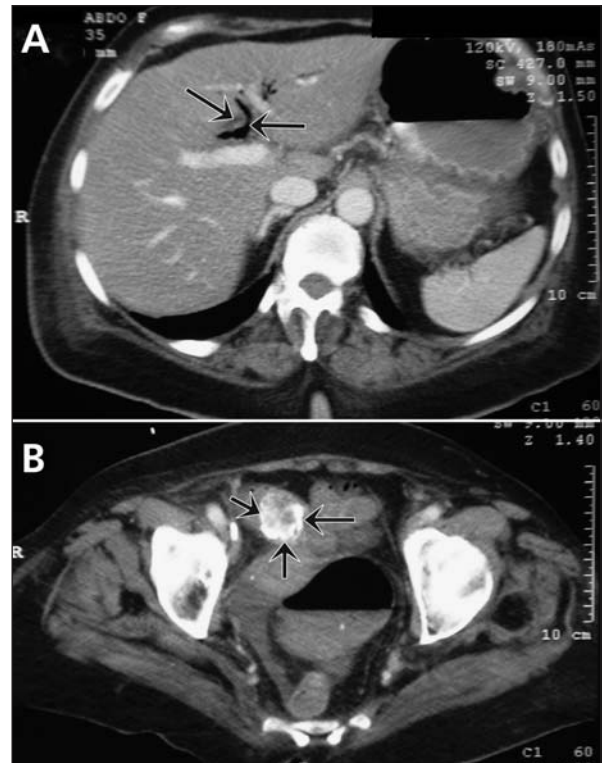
Multidetector computed tomography scans, showing air in the biliary tree (A, arrows) and an ectopic gallstone in the intestinal lumen (B, arrows).
